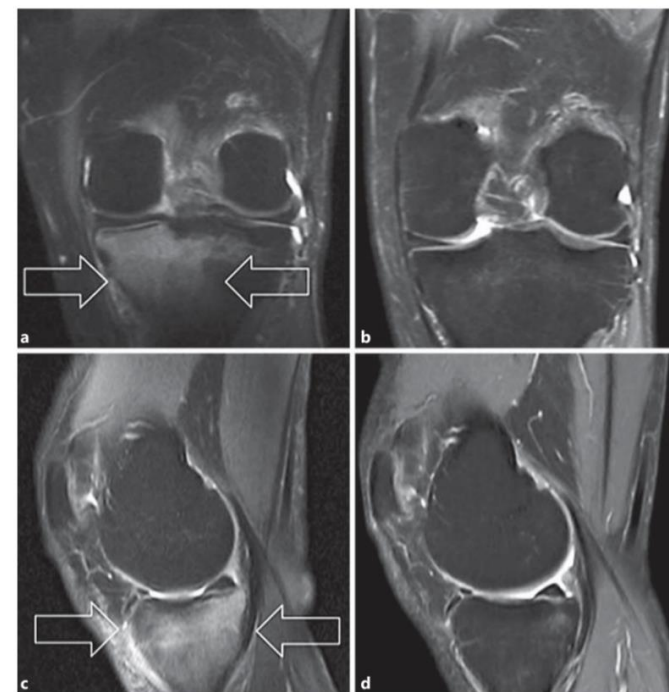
MR images of a patient treated with shock wave therapy. The fat-suppressed fast spin echo T2W MR images show the reduction in the hyperintense signal of the subchondral tibial plateau bone (arrows) from before treatment to the 6-month follow-up in the coronal plane (a, b) and the sagittal plane (c, d).
